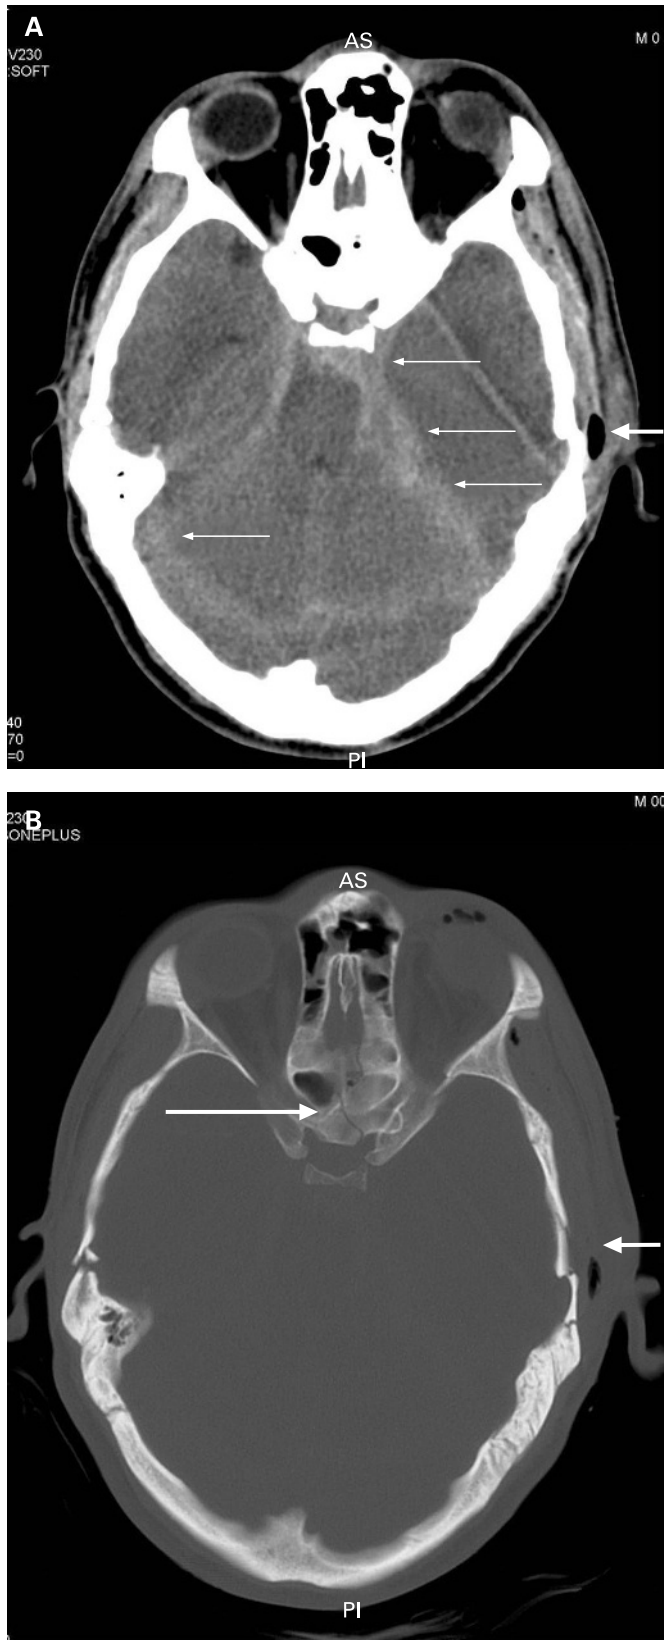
CT examination of the head for trauma. The first image shows extensive subarachnoid blood (arrows) as well as subcutaneous emphysema (large arrow). Post-processing the same image to look at the bones clearly shows the multisegmental temporal fracture and the sphenoid fracture.
